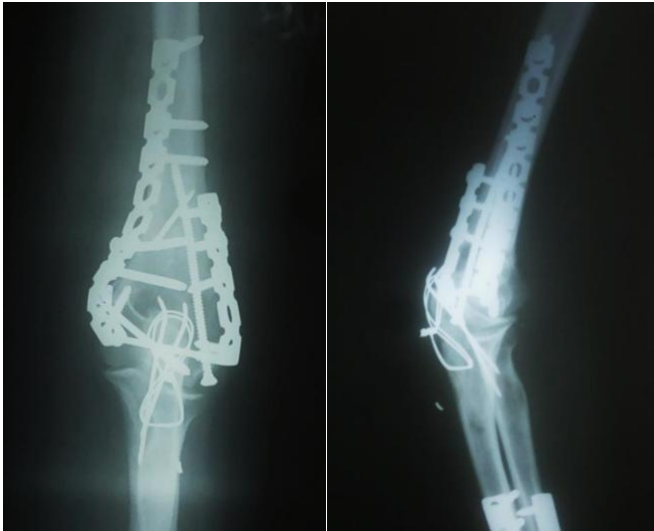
Case 2-29 yr. old female. MOT: RTA. Type and side: LT distal humeral fracture. Fracture pattern: C3. Associated fractures: none. Time till surgery: 5 days. Approach: Olecranon osteotomy. Follow up X-ray at 6 months. complete union .ROM: flexion-extension 10°-130°. MEPS 100 points.
